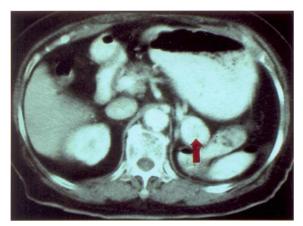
Abdominal CT scan showed a 3 cm enhanced tumor at the tail of the pancreas (arrow) after nephrectomy 12 years but it was not detected
